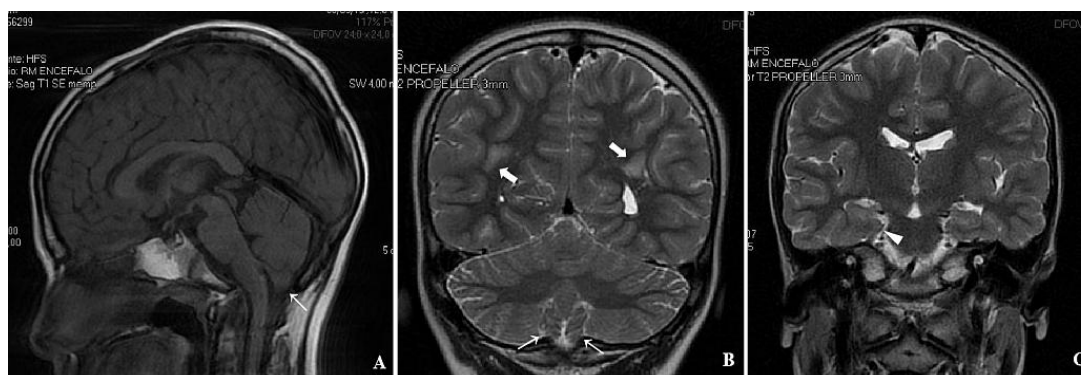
MRI images. Sagittal T1 SE. (A) The CC is normal. Note the slight protrusion of the cerebellar tonsils into the foramen occipitale (thin arrow). Coronal T2 SE; (B) White matter abnormalities are present bilaterally (filled arrows). The slight protrusion of the cerebellar tonsils is confirmed. Coronal T2 SE; (C) In the right hippocampus, the subiculum and Ammon's horn are distinguishable with difficulty and the gray and white matter are blurred (filled arrowhead). The left hippocampus shows normal morphology. However, the entire temporal lobe appears underdeveloped with hyperfolding of its most inferior convolutions.
